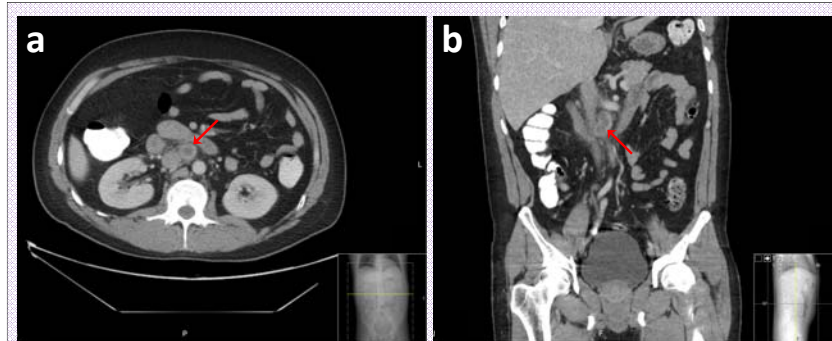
Abdominal computed tomography scan demonstrates solitary enlarged retroperitoneal lymph node (arrows) with central area of hypodensity, located posterior to transverse duodenum, measuring 1.8 x 2.1 x 3.9 cm. (a) Axial image. (b) Coronal image.
